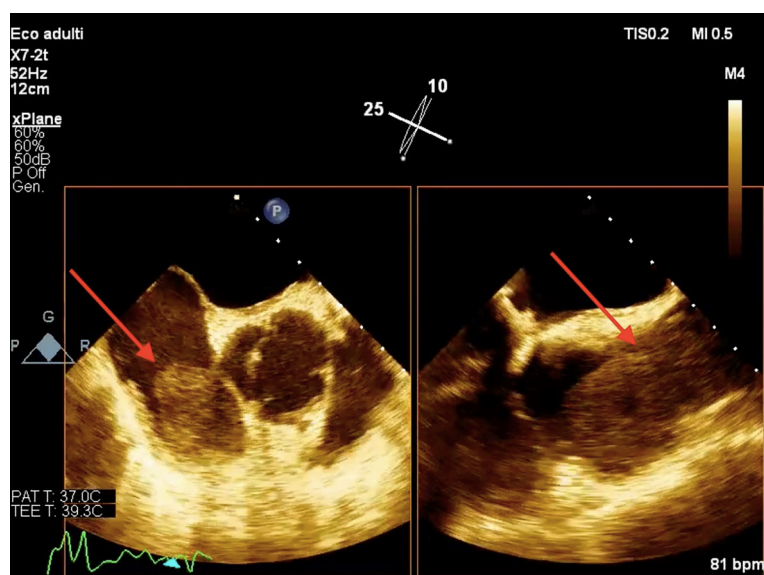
Transesophageal echocardiography image of tumoral invasion of superior vena cava and right atrium in a 72-year-old patient with malignant thymoma (red arrows). PAT T, patient's temperature; TEE T, transesophageal echocardiography probe temperature; TIS, Soft Tissue Thermal Index; MI, Mechanical Index.
